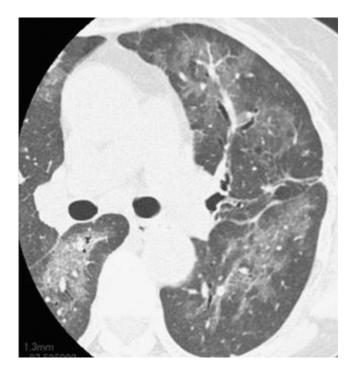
Drug-induced lung injury (DLI), hypersensitivity pneumonia (HP)like pattern. Methotrexate (MTX)-induced lung injury (HP-like pattern) in a 67-year-old woman with dyspnea who had been treated with MTX for 1 month. High-resolution computed tomography, showing diffuse ground-glass opacity, without structural distortion. The patients discussed in Figures 4–6 changed medications just before the onset of signs. These patients should be considered as DLI after exclusion of infection.
